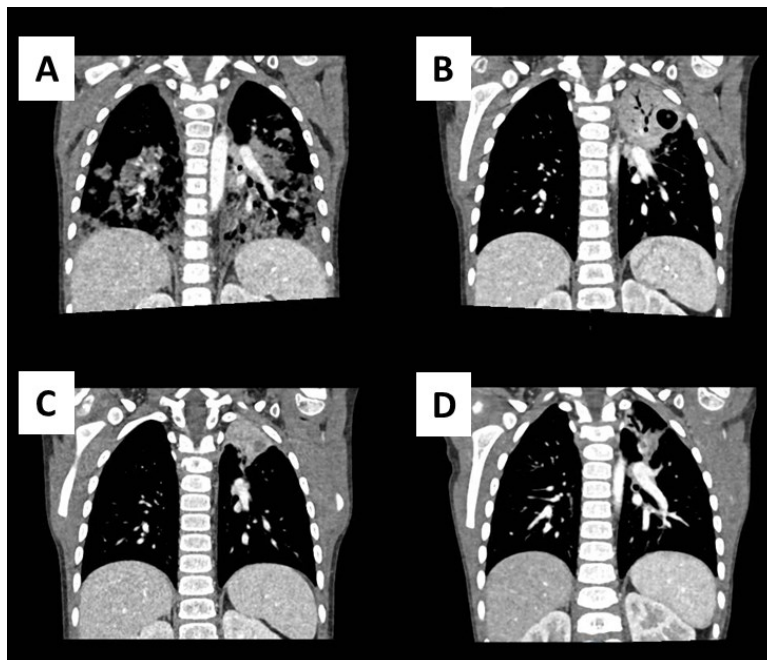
CT scans: A- bilateral infiltrates. B-C cavity evolution. D- further pulmonary improving.
